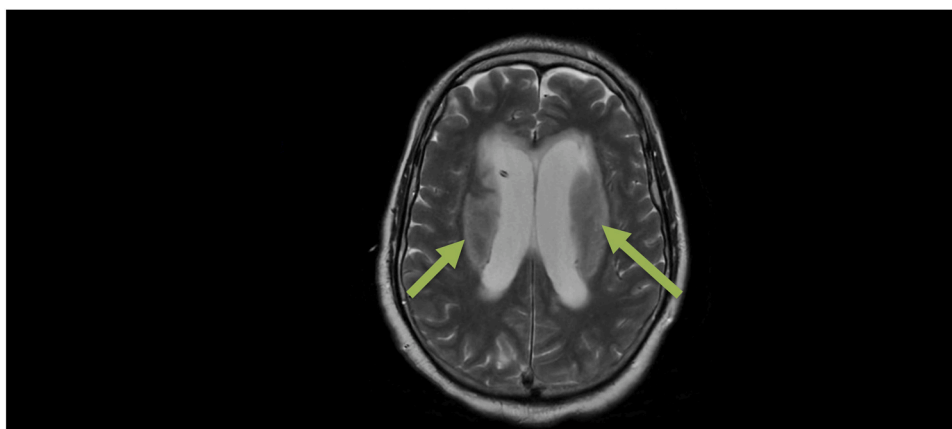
MRI brain revealing evidence of hydrocephalus.
